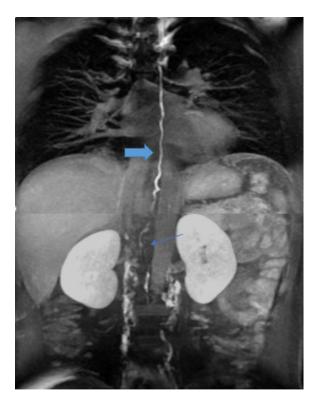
MRI lymphangiography through the inguinal lymph nodes revealed no damage to the cisterna chyli (thin arrow) or thoracic duct (block arrow).
